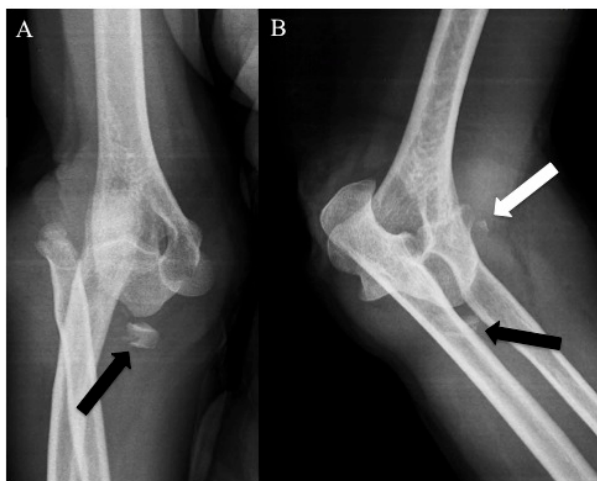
Anteroposterior (A) and lateral (B) radiographs showing a posterolateral dislocation of the right elbow prior to reduction. Fractures of the radial head (black arrows) and the coronoid process of the ulna (white arrow) are depicted.
